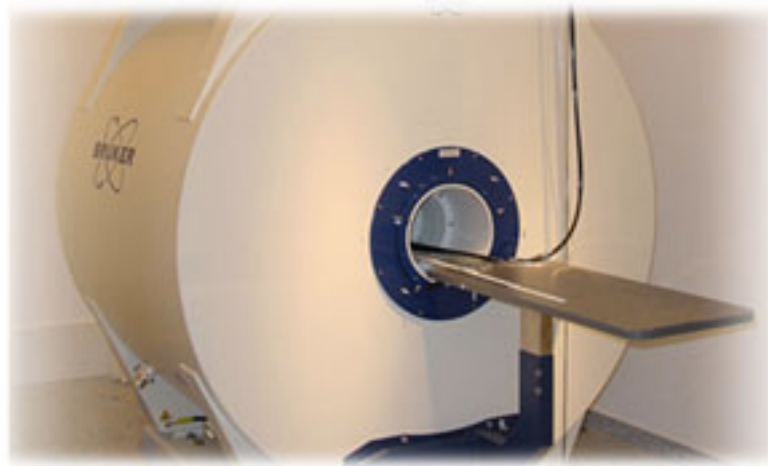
9.4 Tesla MRI (Bruker Biospec, Ettlingen, Germany).
